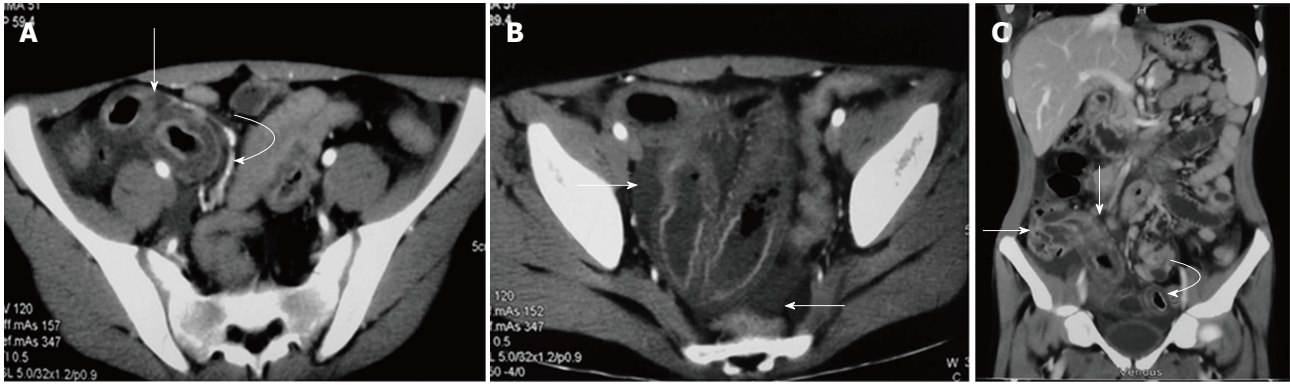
Bowel involvement in Henoch-Schonlein purpura in a 15-year-old male. A: Contrast enhanced axial computed tomography (CT) image in the arterial phase shows circumferential wall thickening involving a distal ileal loop (arrow) with mural stratification. Engorged mesenteric vessels are seen adjacent to the thickened bowel (curved arrow); B: Axial CT image at the level of pelvis shows free fluid (arrows) and thickening of ileal loops; C: Coronal multiplanar reformatted image shows long segment thickening involving terminal ileum and ascending colon (straight arrows). Another segment of distal ileal loop also shows wall thickening (curved arrow).
